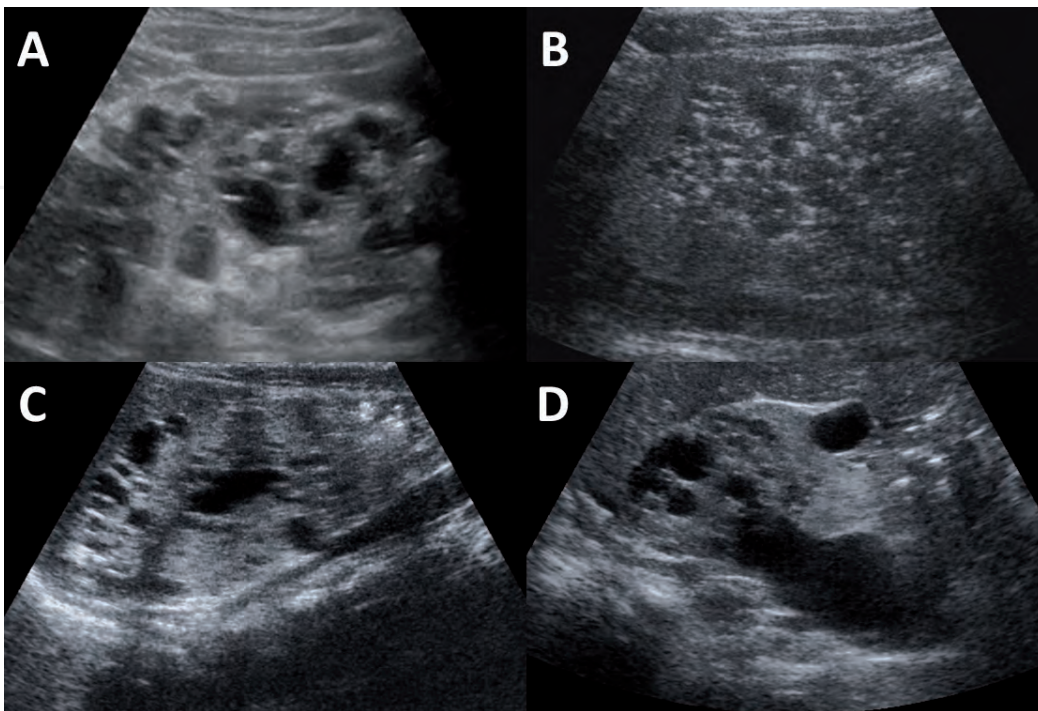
Ultrasound images of different renal cystic diseases, autosomal dominant polycystic kidney disease (A), autosomal recessive polycystic kidney disease (B), acquired cysts after chronic dialysis with end stage renal disease (C), and cystic renal dysplasia of newborn (D).
